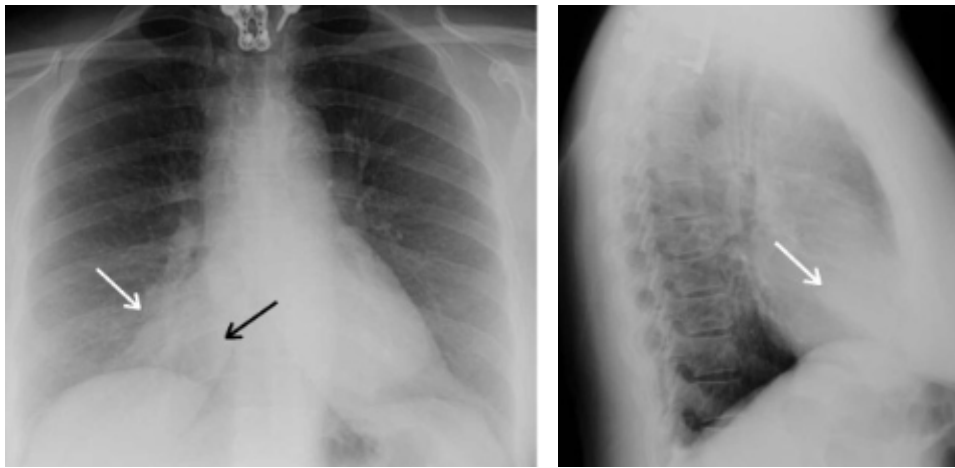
Chest X-ray, abnormal mass lesion at the lateral side of the right ventricle.(from archive radiology)
